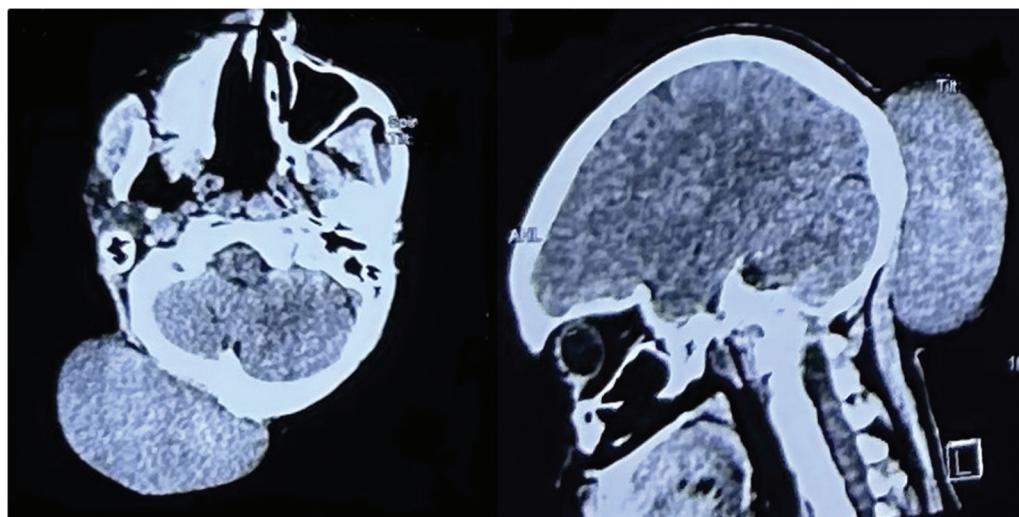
Preoperative computed tomography brain plain axial and sagittal image showing the tumor with no intracranial extension.
